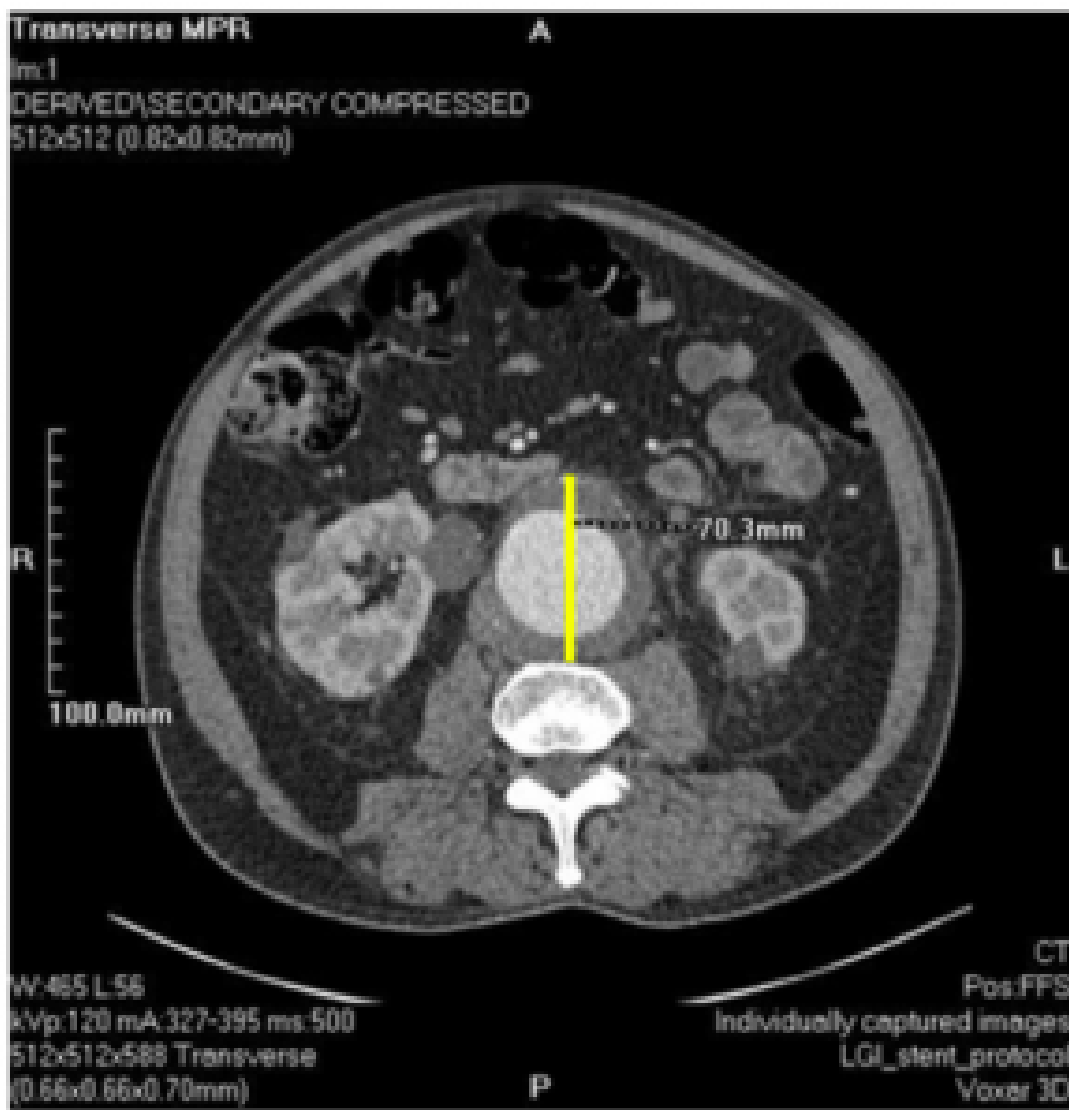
CT aortogram shows a rapid increased 7.0 cm (yellow line) size of the AAA in the anteroposterior diameter. This also shows sign of impending rupture and beak in left lateral aortic thrombus.¹
